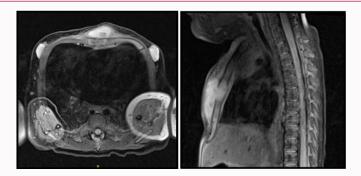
MRI Thorax: Detection of a circumscribed subcutaneous presternal abscess (2.5 cm × 0.8 cm × 3.0 cm), extension of inflammation/osteomyelitis to the corpus sterni with destruction of the anterior and posterior cortical and infiltration to intrathoracal precardiac.
